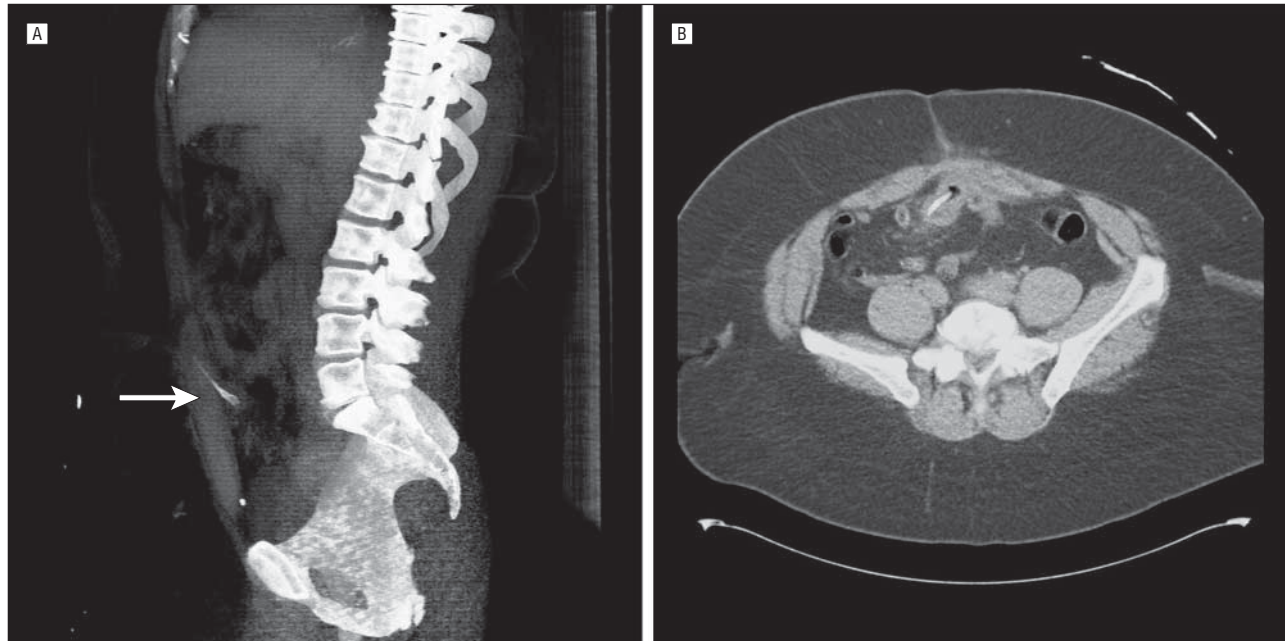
Abdominal computed tomographic scan. A, Sagittal reconstruction from high-resolution computed tomography showing calcified radiodensity abutting the anterior abdominal wall (white arrow). B, Axial computed tomography with a 5-cm-long radiodensity in the mid small bowel directly abutting the anterior abdominal wall with surrounding inflammation and bowel wall thickening.
